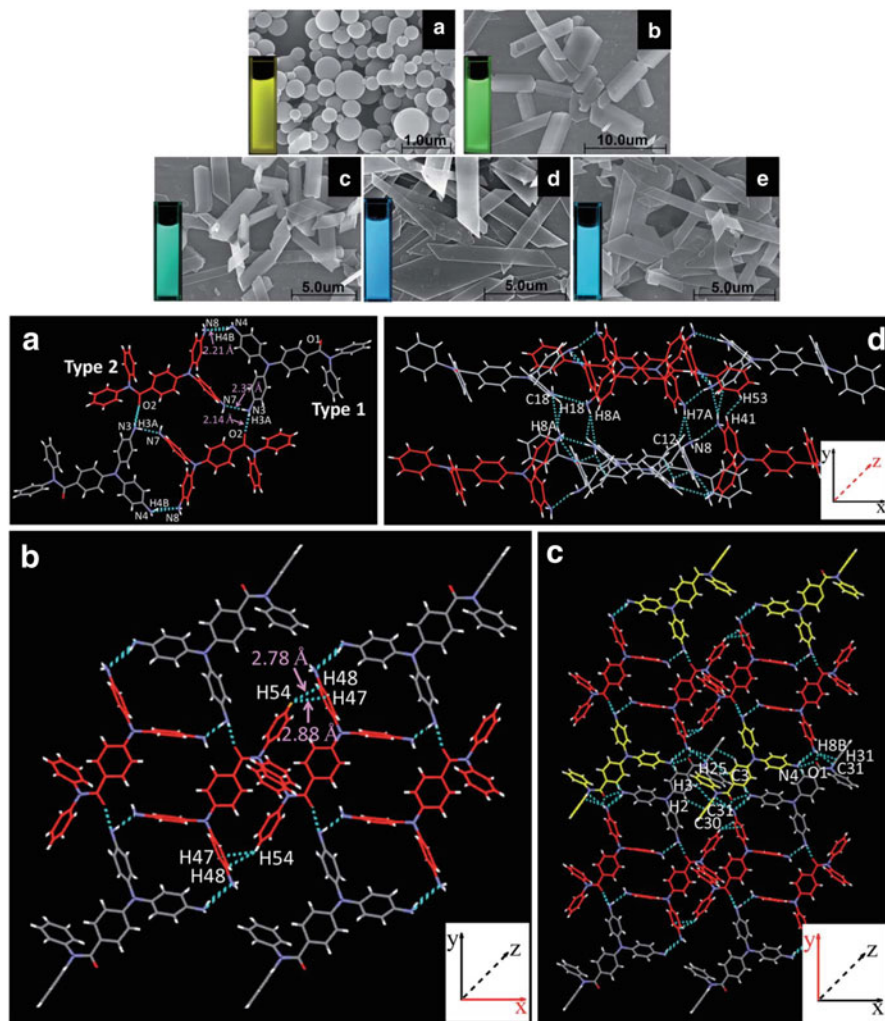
Top*: Influence of US power (40 kHz) on the morphology and fluorescence color of ITPADA suspensions in THF-H₂O mixtures (90% water content): (a) non-ultrasonic; (b) 80 W; (c) 120 W; (d) 160 W; (e) 200 W. *Bottom*: Crystal packing of ITPADA single crystals: (a) basic unit of single crystals; (b) interactions along the x-axis; (c) interactions along the y-axis; (d) interactions along the z-axis. Reproduced with permission from [59]. Copyright 2014 The Royal Society of Chemistry
